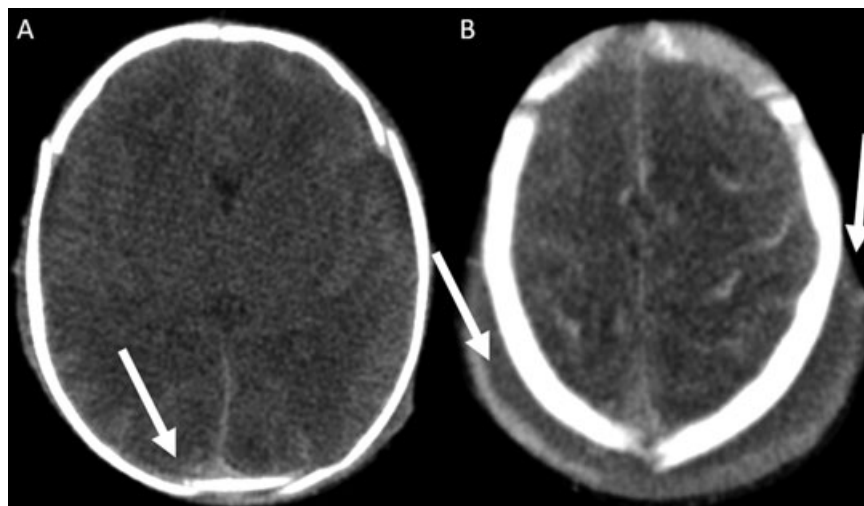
Axial noncontrast enhanced axial CT images (A, B) of a newborn baby (35 week gestation). CT shows parietal bone fractures, subgaleal hematoma crossing the suture lines, subarachnoid blood within the sulci near the vertex and mild global edema as complication of a failed vacuum extraction.
